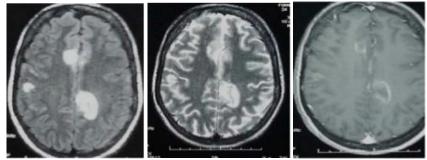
MRI in axial section shows: A: FLAIR sequence: shows three cortical lesions in hyper signal. B: T2 sequence, the three lesions are in T2 hyper signal. C: T1 sequence with gadolinium injection, shows annular enhancement of the three lesions
